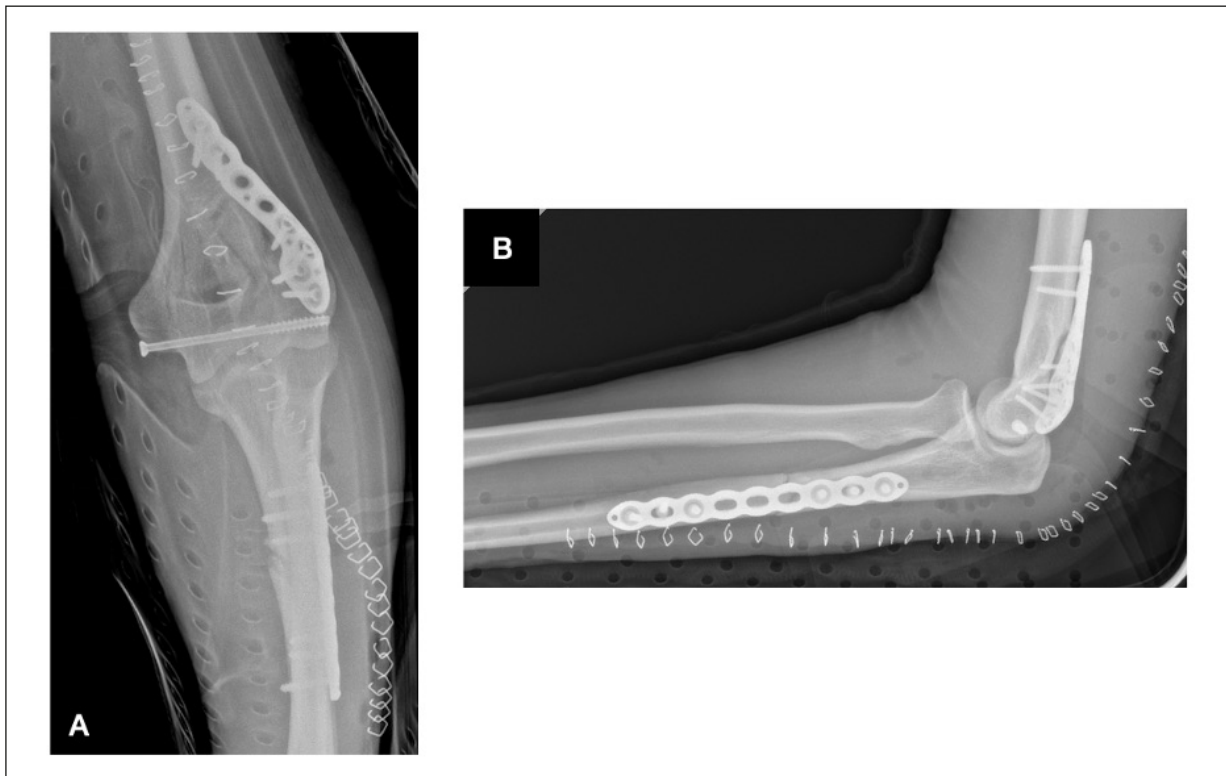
A, Antero-posterior post-operative x-ray; (B), x-ray in lateral projection of the elbow showing the reduction and synthesis of the fractures obtained with the implantation of plates and screws.
